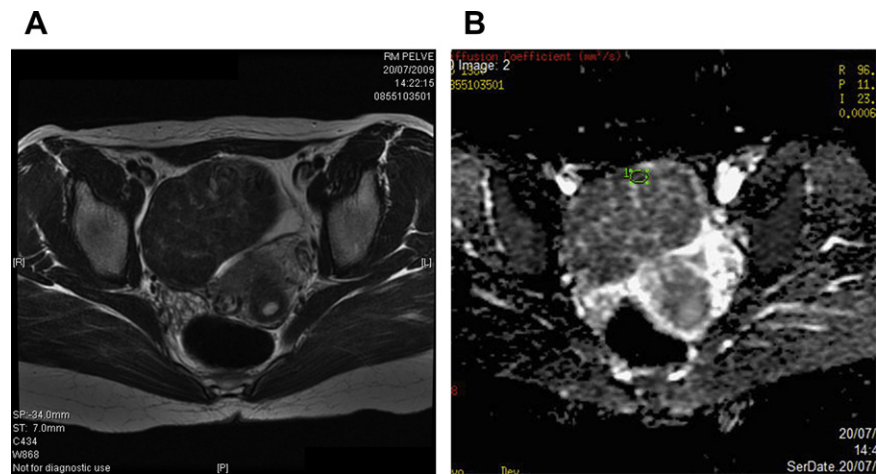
Hyalinized leiomyoma. (A) Hypointense on T2-weighted image. (B) Hypointense signal on the ADC map.
